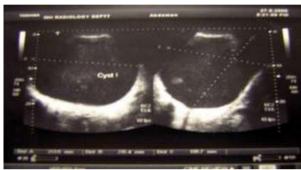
Abdominopelvic sonogram of patient showing a large cystic mass located just above the uterus.
